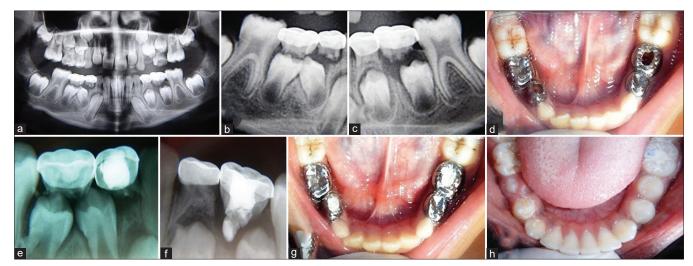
(a) Orthopantomograph; (b) magnified view of orthopantomograph (lower right side); (c) magnified view of orthopantomograph (lower left side); (d) lower occlusal view; (e) posttreatment radiograph (right side); (f) posttreatment radiograph (left side); (g) posttreatment lower occlusal view; (h) lower occlusal view after eruption of premolars
